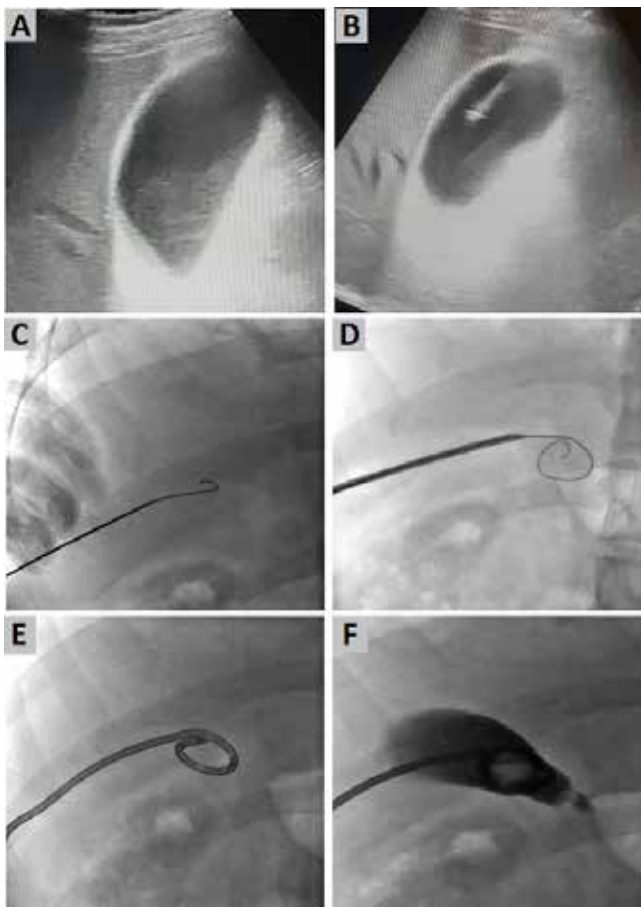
Percutaneous cholecystostomy of a 64-year-old male patient with findings of acute cholecystitis and an APACHE II score of 16. (A) Diffuse wall thickening and sludge in the lumen of the gallbladder was observed in the ultrasonographic examination. (B) An 18G Chiba needle was punctured to the gallbladder fundus by transperitoneal route under ultrasonography guidance. (C, D) The guidewire was introduced and (E) the catheter was placed under fluoroscopy. (F) The control image confirms that the catheter was placed exactly in the gallbladder lumen. APACHE II: acute physiology and chronic health evaluation II score.
